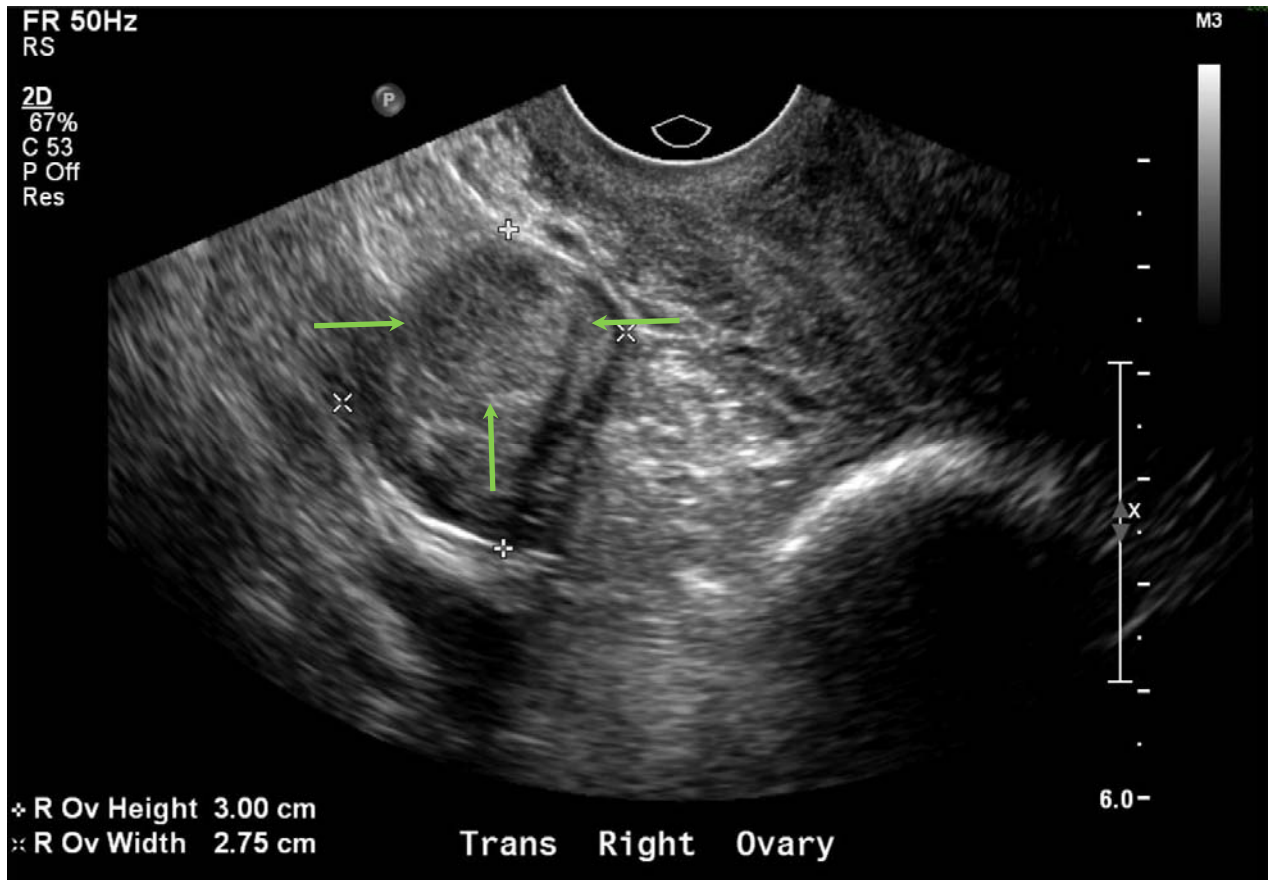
Endovaginal transverse grayscale ultrasound image of the right ovary, which is normal in size and measures 2.6 x 3.2 x 2.7 cm. The right ovary displays no contour abnormality and contains a distinctly seen well-circumscribed, homogeneously echogenic solid mass (indicated by the green arrows).
